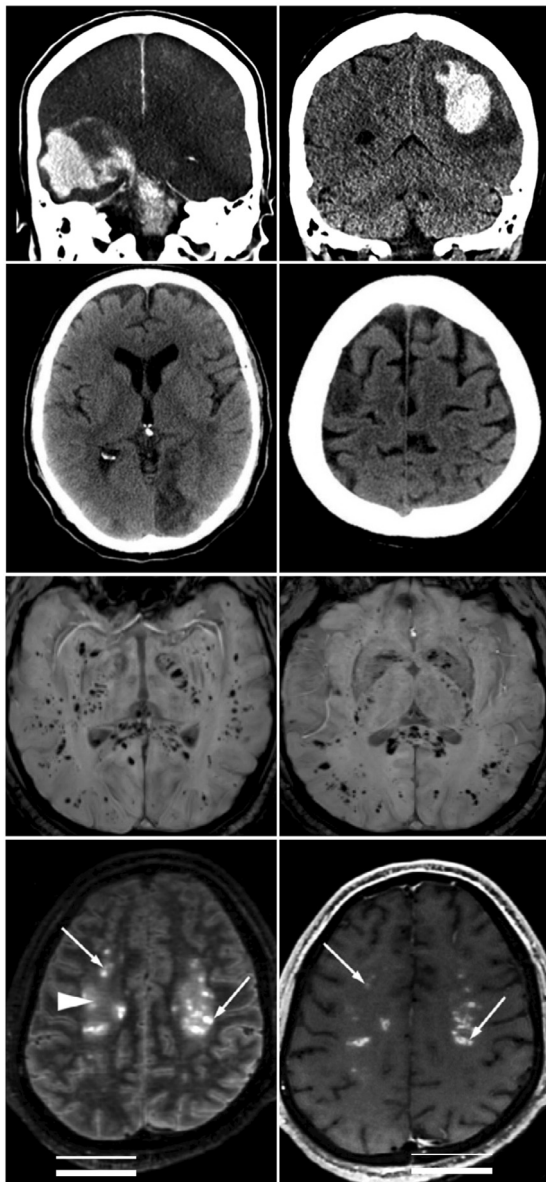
Neuroimaging findings in patients with severe COVID-19 infection. Head CT depicting (a) extensive acute intracranial hemorrhage in a 74-year-old man with absent brainstem reflexes following uncus, subfalcine, and transtentorial herniation and (b) left parietal intraparenchymal hemorrhage with surrounding vasogenic edema in a 61-year-old woman with right-sided weakness and numbness (13). (c,d) Noncontrast head CT showing two different ischemic lesions in the left occipital and right frontal lobes of a 64-year-old man with elevated coagulation tests (65). (e,f) Axial susceptibility weighted imaging of extensive microhemorrhages in a 57-year-old man, primarily in the subcortical white matter, corpus callosum, internal capsule and cerebellar peduncles (10). (g,h) White matter abnormalities that are hyperintense on axial T2 FLAIR imaging (g) and show perivascular enhancement on postcontrast T1-weighted images (h) in a 37-year-old male who developed ARDS and multiple organ failure (14). Panels a and b reproduced from Radmanesh et al. (13) with permission from the American Society of Neuroradiology, panels c and d reproduced from Morassi et al. (65) with permission from Springer Nature (COVID-19 PMC Open Access Subset). Panels e and f reproduced from Kremer et al. (10) and panels g and h reproduced from Chougar et al. (14) with permission from the Radiological Society of North America (COVID-19 PMC Open Access Subset).
